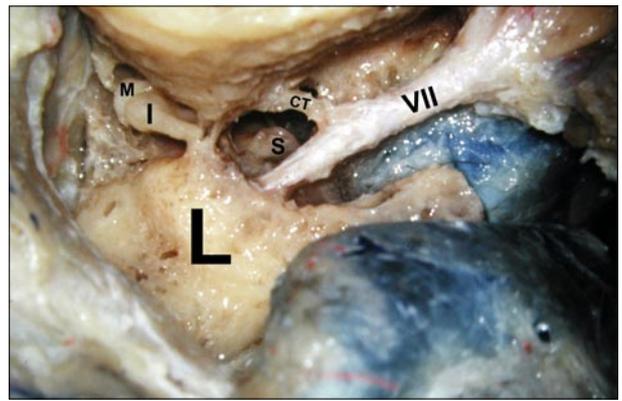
Opening of the stylomastoid foramen and the fallopian canal via right transpetrosal approach enables mobilization of the mastoid and extracranial segments of the facial nerve (VII). (L: labyrinth, I: incus, M: malleus, S: stapes, CT: chorda tympani)
